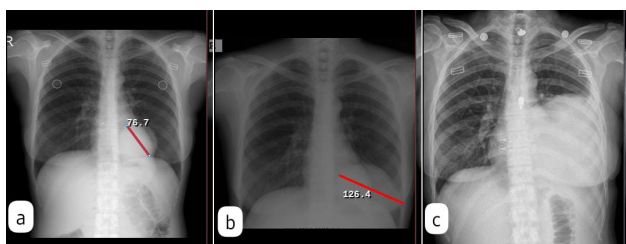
a) In the preoperative radiograph taken approximately 2 years prior, a lesion measuring 76.7 mm in size is observed within the contours of the heart. b) In the radiograph taken one year before surgery, the lesion was noted to extend from the cardiac silhouette to the diaphragm, measuring approximately 126.4 mm. c) X-ray imaging of the giant hydatid cyst on the diaphragm, where the boundaries could not be distinguished from the cardiac contour.
